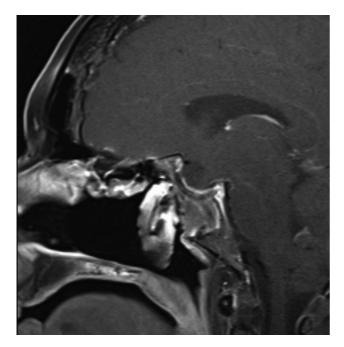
Long-term surveillance magnetic resonance imaging demonstrating enhancing lateral nasal wall flap for closure of a suprasellar and sellar defect.
